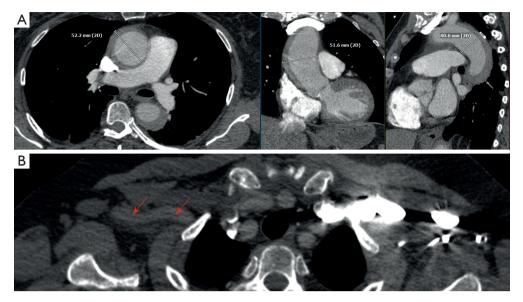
Preoperative CT angiography. (A) Acute aortic dissection Stanford type A, DeBakey I as an intramural hematoma. (B) Dissection of the right subclavian artery (arrows). CT, computed tomography.
